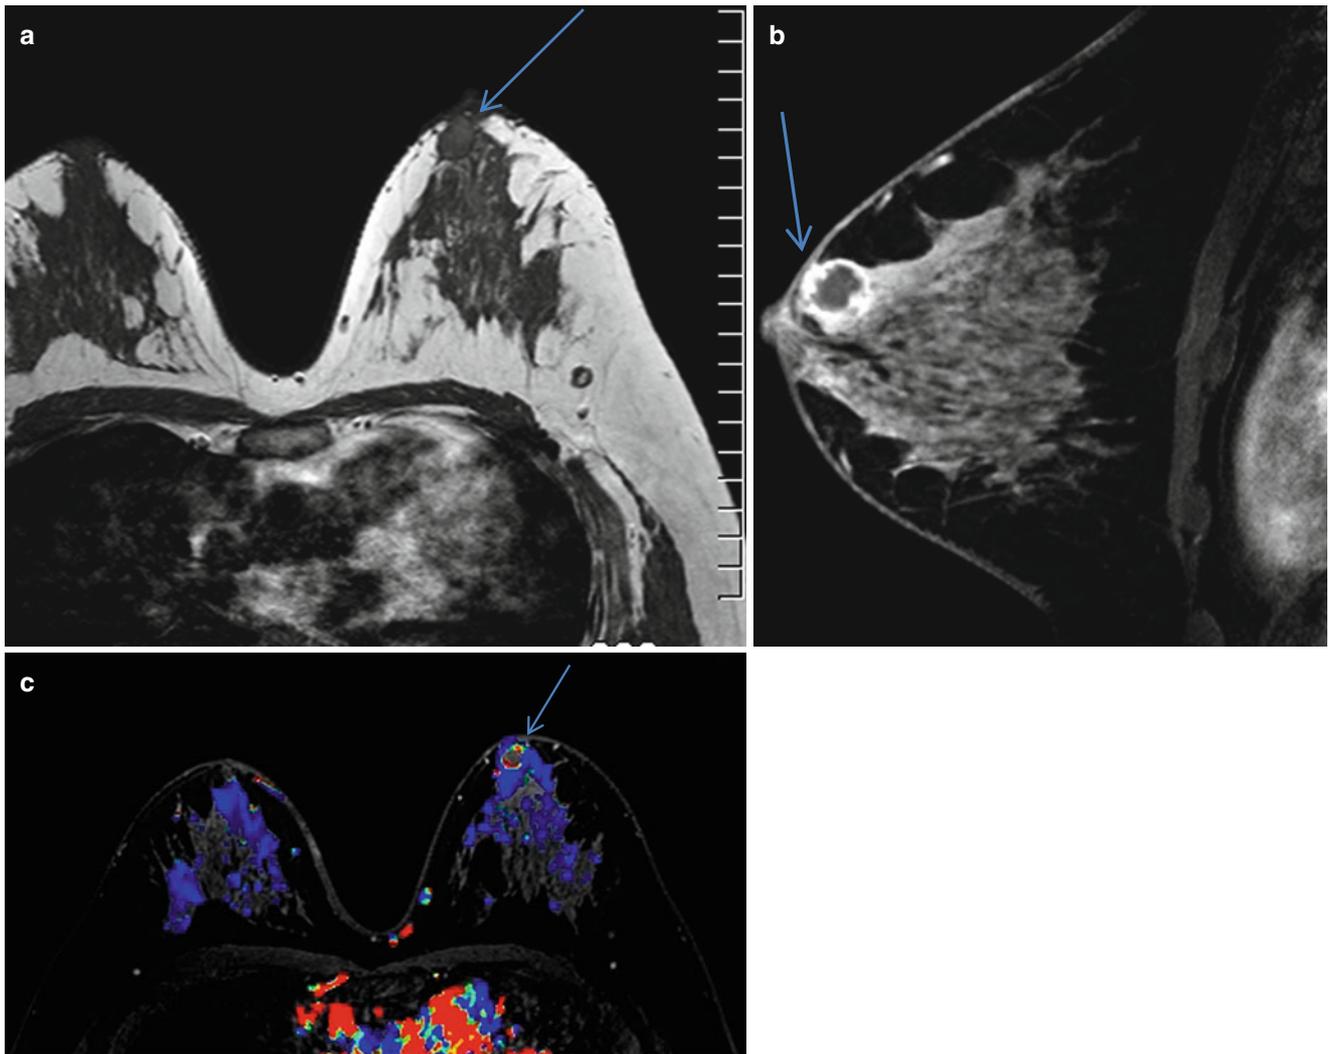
(a) Axial T1-weighted image shows an isointense mass with lobulated borders in the subareolar left breast. (b) Axial postcontrast fat-suppressed T1-weighted image shows an enhancing lesion with irregular thick rim enhancement suspicious for malignancy. (c) Axial
